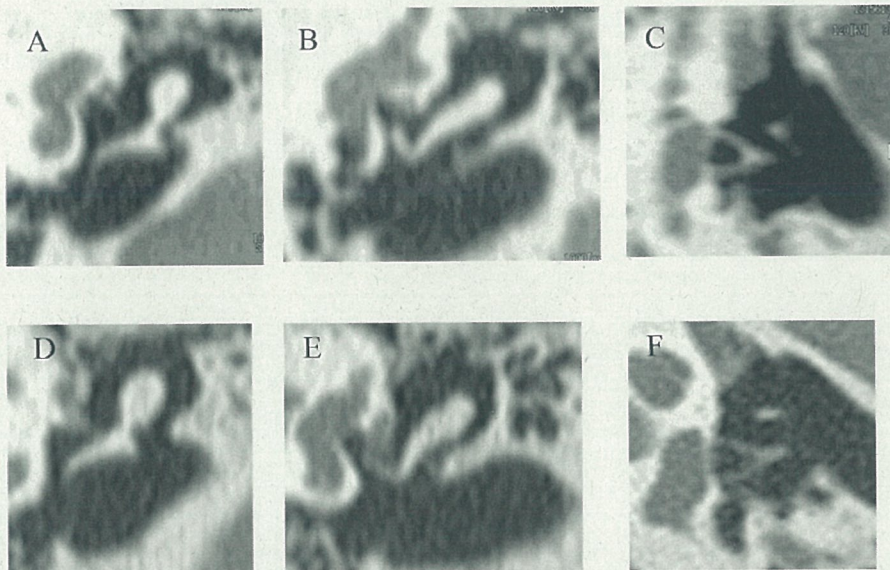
MPR images using 4- and 64-detector row CT scanners in normal ossicles. The upper images (A–C) and the lower images (D–F) were made using 4- and 64-detector row CT scanners, respectively. Left: malleus, middle: incus, right: stapes.
